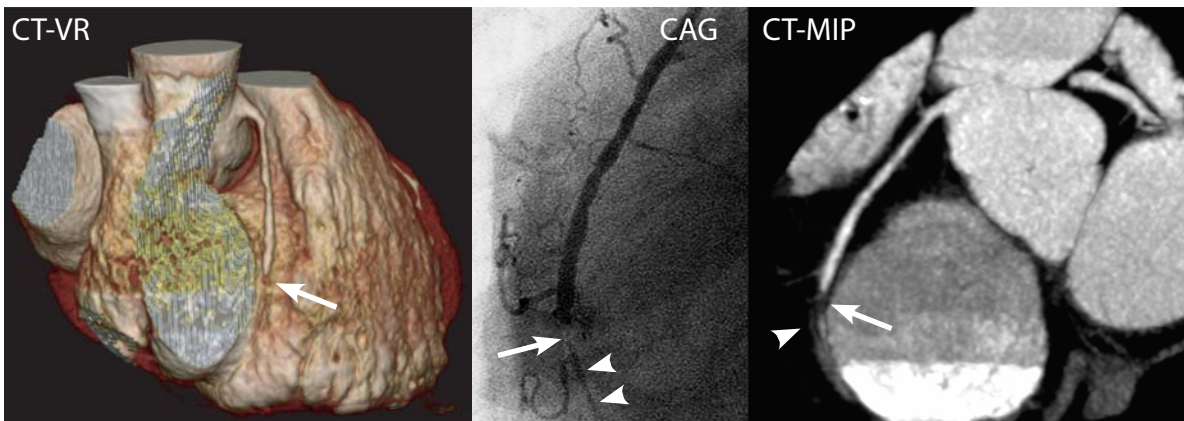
An occlusion of the RCA examined with 16-slice CT. Complete occlusion (*arrow*) of the RCA with minimal retrograde filling of the distal part (*arrowhead*) can be appreciated using MIP or 3D VRT, and is confirmed by CAG
